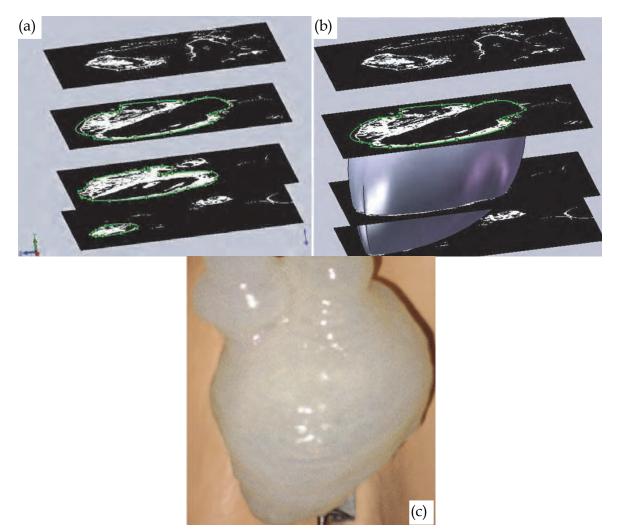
Overview of the pseudo-volume rendering method. (a) Graphical zone of SolidWorks, that includes the CT-scan images, the spline curves in green. (b) The smoothed surface of the heart wall from the spline curves. (c) finalized heart model with its aortic roots. Reproduced from Abdel-Sayed P, Kalejs M, von Segesser LK. A new training set-up for trans-apical aortic valve replacement. Interac CardioVasc Thorac Surg 2009; 8: 599-601, with permission of the European Association of Cardio-Thoracic Surgery.
